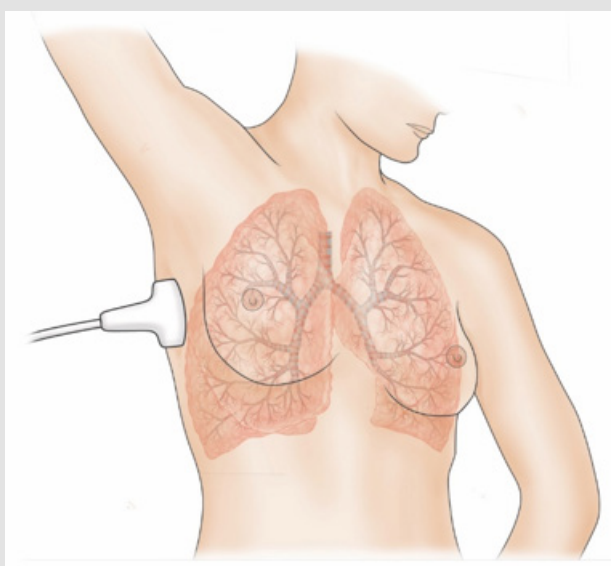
Position of the probe for transaxillary lung ultrasound ‘biopsy’.
